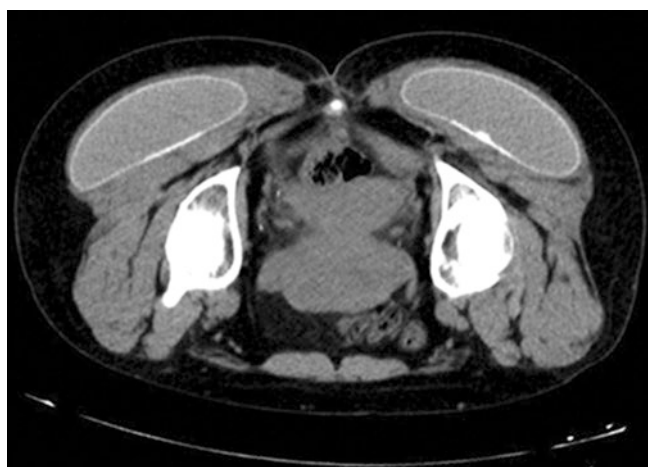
Computed tomography scan showing the gluteal implants placed intramuscularly. (From Serra et al. [10]; used with permission)
